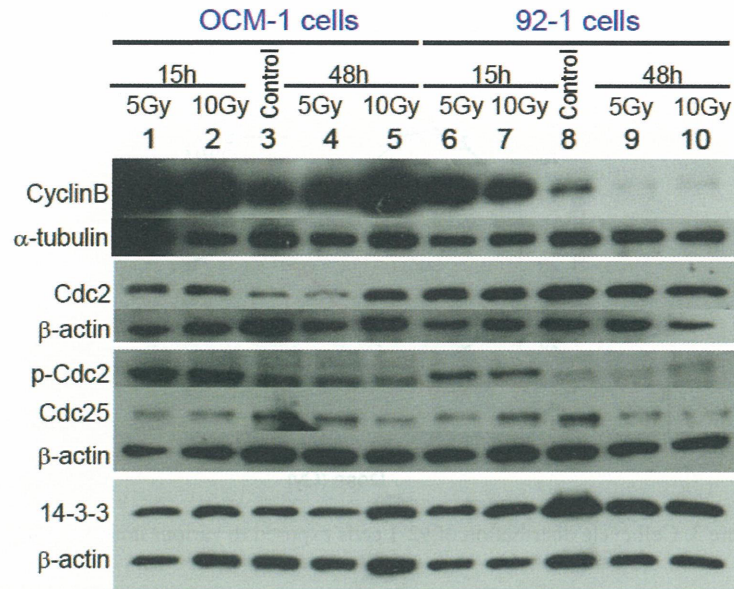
Gene expression induced by X-rays
